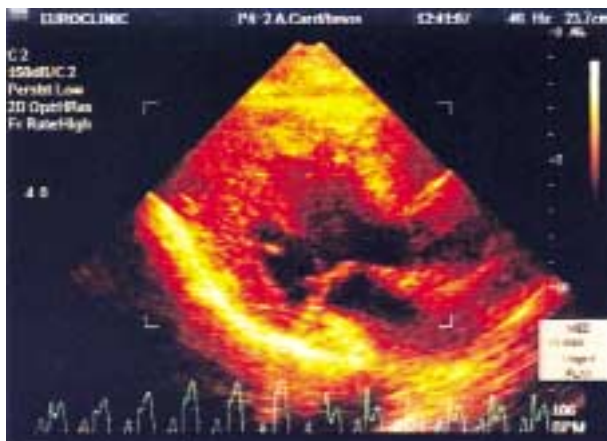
Long parasternal axis view after the onset of acute myocardial infarction with ST segment elevation during dobutamine stress echo study. At the bottom of the figure the simultaneous continuous rhythm monitoring is depicted, with ST segment elevation and the moment of the onset of sustained ventricular tachycardia.
